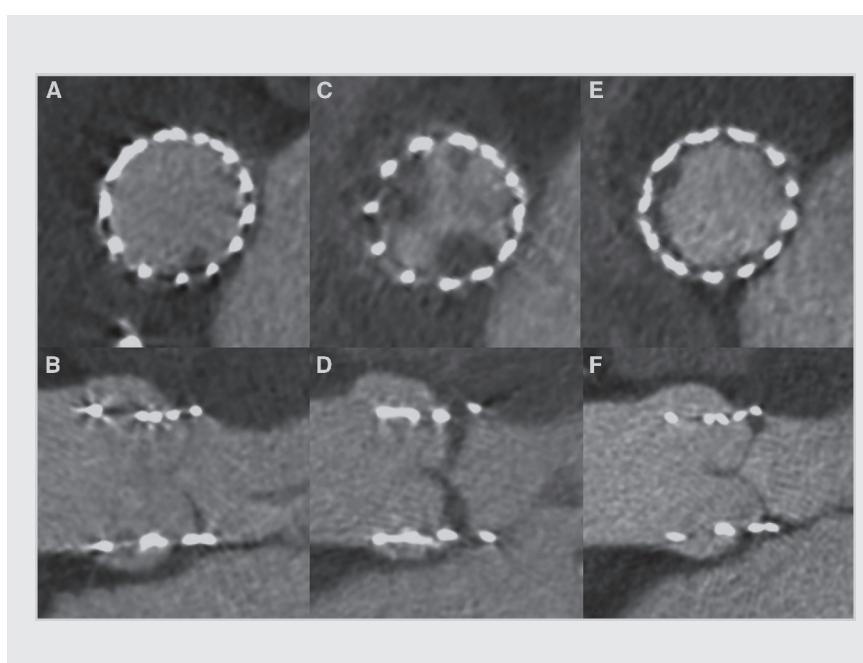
Axial and sagittal oblique reconstructions of a CORONARY CTA scan in an 80-year-old female immediately after implantation of a balloon-expandable transcatheter aortic valve prosthesis (A and B), at 3 months- (C and D), and at 6 months-follow-up (E and F). Note subtle early hypo-attenuated thickening (HALT) of the non-coronary cusp (A and B) which progressed to 5 mm thickening of the non-coronary cusp and included the right coronary cusp (C and D). After a combination of clopidogrel and phenprocoumon follow-up coronary CTA showed almost complete resolution of HALT. (E and F).
